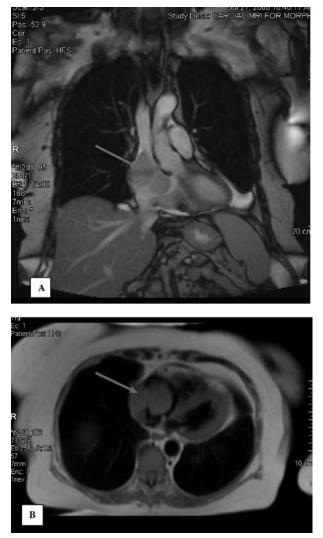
Cardiac MRI demonstrating (A) intracardiac involvement of diffuse large B-cell lymphoma (arrow) originating from right atrium and (B) involvement of right ventricular myocardium (arrow).
